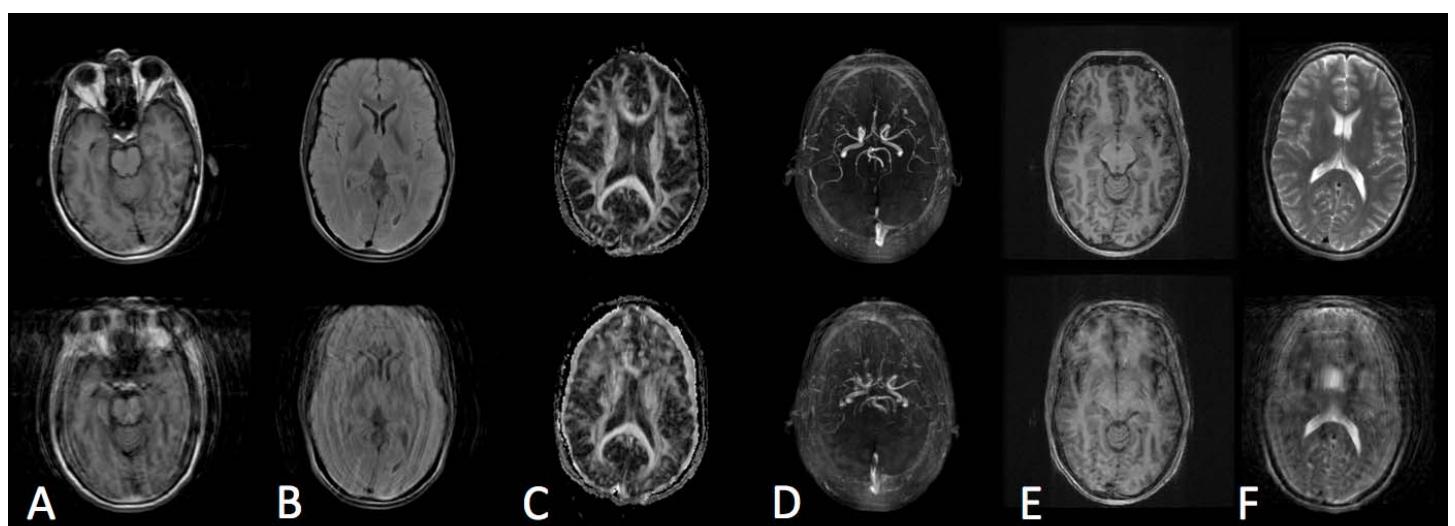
Results of the in vivo experiments using neuroimaging protocol on healthy subjects with the prospective motion correction off (bottom row) and on (top row): (A) T1 FLAIR, (B) T2 FLAIR, (C) DTI, (D) 3D TOF, (E) BRAVO and (F) FSE
